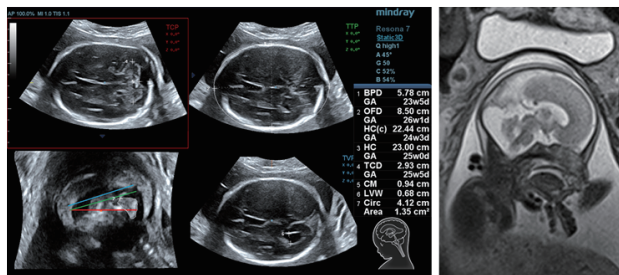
MSP and MRI images of case 2, which was misdiagnosed as Dandy-Walker Syndrome from 2D ultrasound, but was corrected by Smart Planes.
